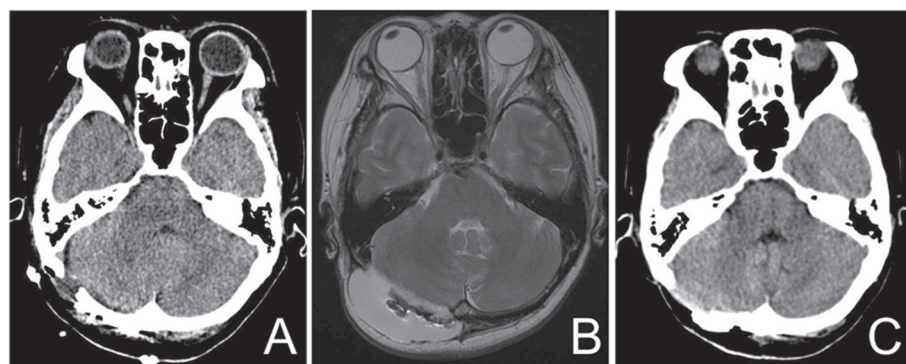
A computed tomography (CT) scan of head one day after first operation (A) showing no apparent pseudomeningocele, an axial magnetic resonance imaging about 5 weeks after first operation (B) showing a pseudomeningocele under operative wound, and a CT scan 2 weeks after second operation (C) showing no pseudomeningocele.
